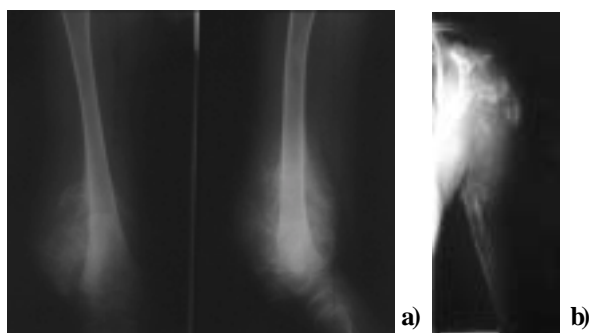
a) X-ray in two orthogonal planes of typical mixed sclerotic and lytic osteosarcoma of the distal femur. Tumor has penetrated bone and formed a soft tissue mass with Codman’s triangles. b) Frontal plane X-ray of osteosarcoma causing pathological fracture on proximal humerus with small, confluent cloud-like densities, destroying the bone completely.
